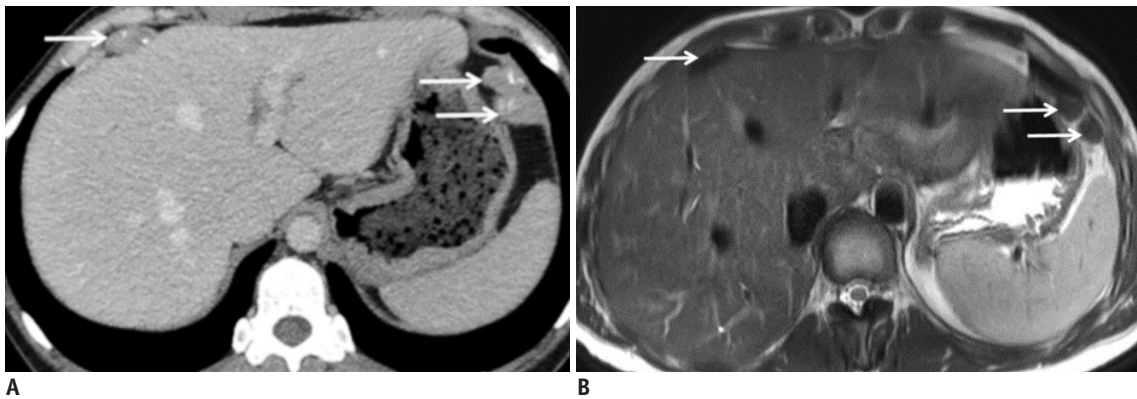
Peritoneal fibromatosis in a 37-year-old female with abdominal pain. A 37-year-old female patient with a history of peritoneal fibromatosis operated on at the age of five with complete cytoreduction complaining of abdominal pain. A. Axial contrast-enhanced CT image displays well-delineated peritoneal nodules containing calcifications, one of which is in the perihepatic space (arrows). B. Axial T2-weighted MR image reveals the fibrous nature of the nodules displaying low signal intensity (arrows).
